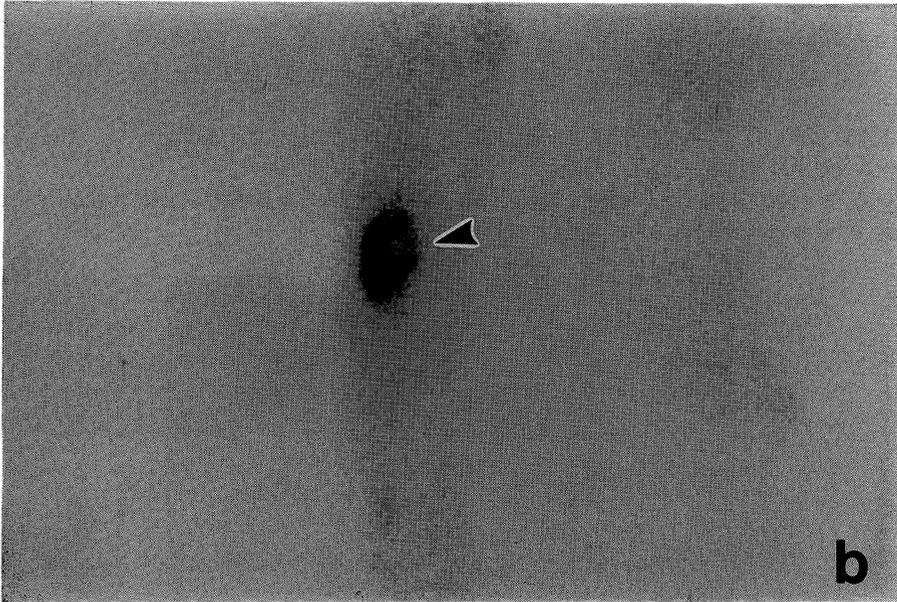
Bone scintigraphy showed cold defect, like a doughnut.
